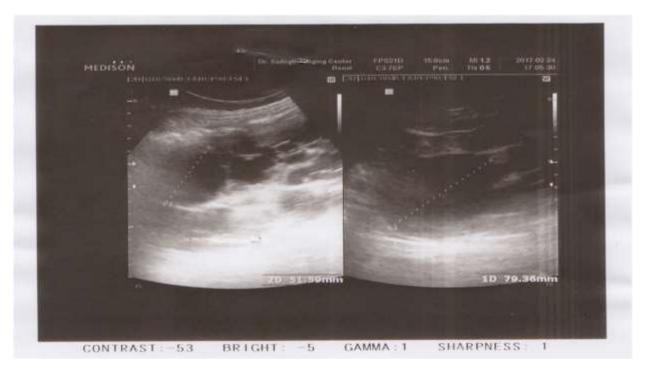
Ultrasound image of kidneys. The size of both kidneys are abnormally enlarged, and in both kidneys there are a number of cystic lesions present, the largest of which are 51 mm in the right kidney and 79 mm in the left kidney.
